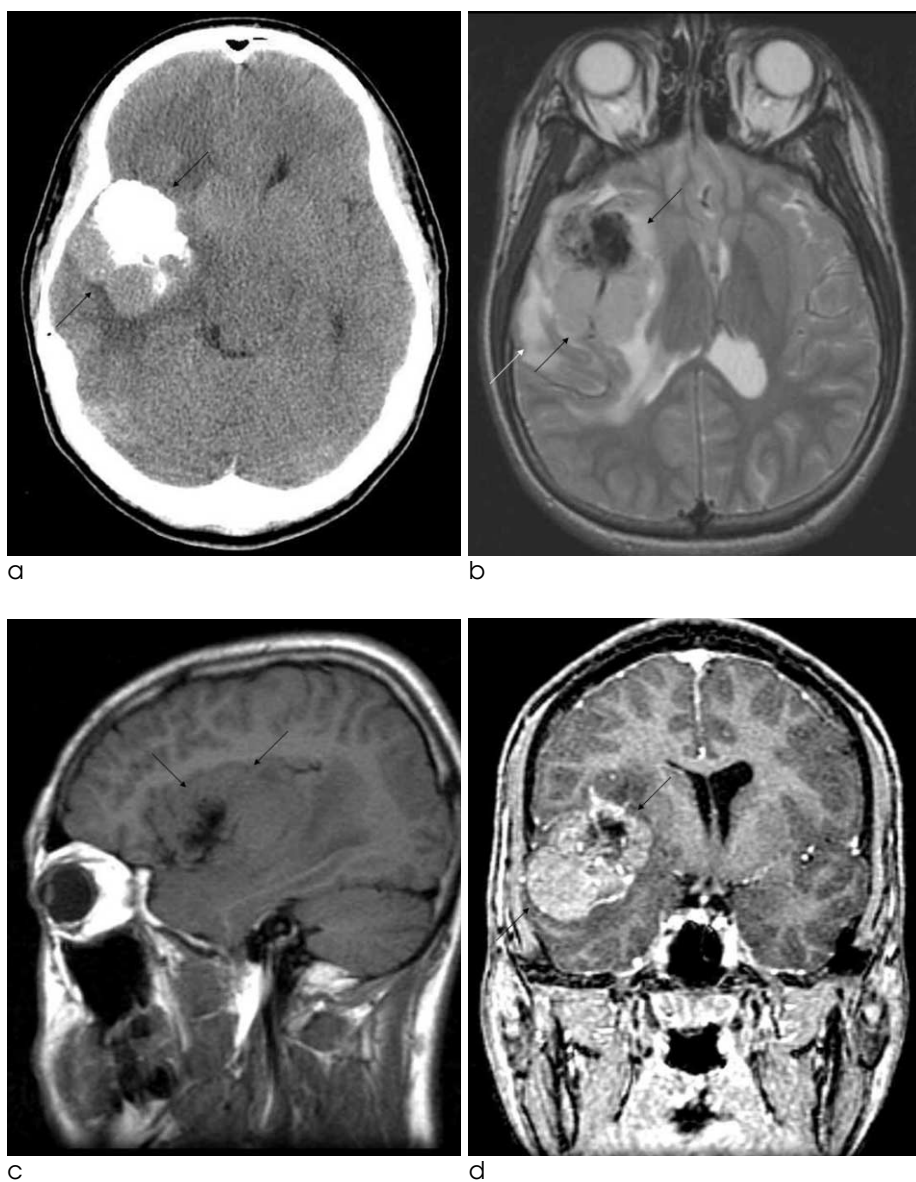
A 16-year-old boy who presented with a tingling sensation. Non-contrast CT scan (a) shows a highly attenuated mass lesion (arrow) with dense calcification in the right temporal lobe. T2-WI image (b) demonstrates a high signal intensity mass lesion (black arrow) with low signal intensity region (suggestive of calcification), and parenchymal edema (white arrow). T1-WI image (c) shows a low signal intensity mass lesion (arrow) with a low signal intensity region, suggestive of calcification. T1-WI contrast enhanced image (d) shows strong enhancement. The pre-operative radiologic diagnosis was of ganglioglioma, but pathologic examination revealed fibrous meningioma.
